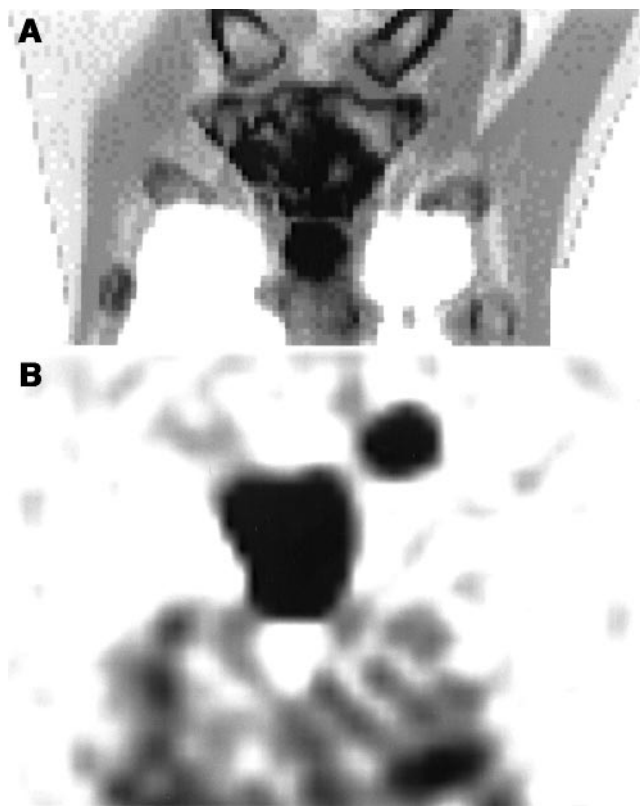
Example of large osteoblastic bone metastases in corpus sterni. (A) Visualization of metastases by coronal slice of CT. (B) Visualization of metastases by coronal slice of ^{188}Re -HEDP SPECT.
